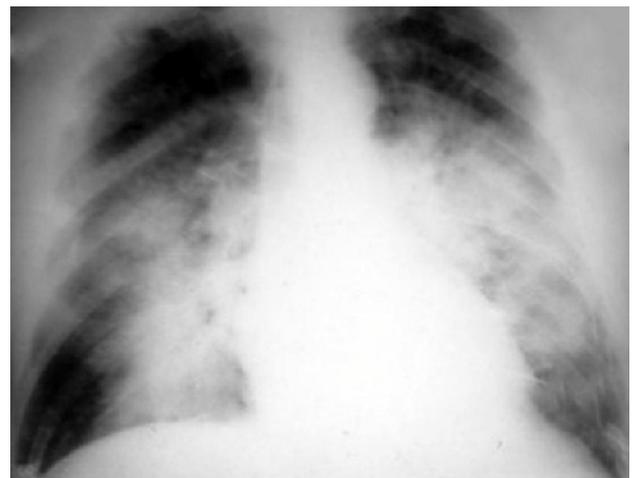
X-ray showing ARDS (which showed bilateral diffused infiltrates with sparing of costophrenic angle)
